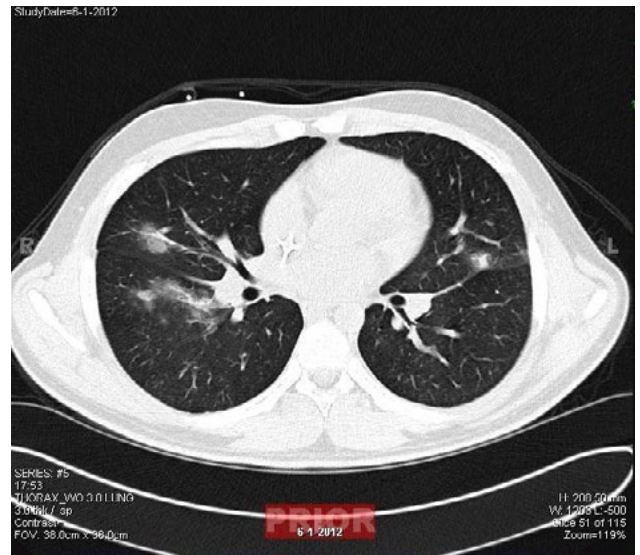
Computed tomography of the chest showed a nodular pneumonia infiltrate consistent with mold infection.
